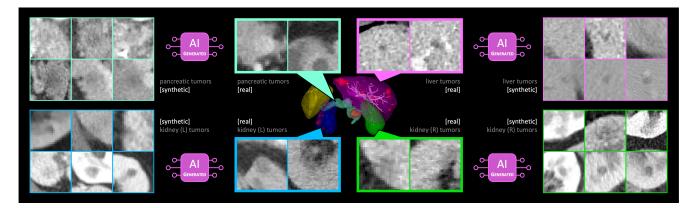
Generalizable tumor synthesis across organs. Early-stage tumors present similar imaging characteristics in computed tomography (CT), whether they are located in the liver, pancreas, or kidneys. Leveraging this observation, we develop a generative AI model on a few examples of annotated tumors in a specific organ, e.g., the liver (in purple). This AI model (in purple), trained exclusively on liver tumors, can directly create synthetic tumors in those organs where CT volumes of annotated tumors are relatively scarce, e.g., the pancreas (in cyan) and kidneys (in blue and green). By integrating synthetic tumors into extensive CT volumes of healthy organs—routinely collected in clinical settings—we can substantially augment the training set for tumor segmentation. This enhancement can also significantly improve the AI generalizability across CT volumes sourced from diverse hospitals and patient demographics.
